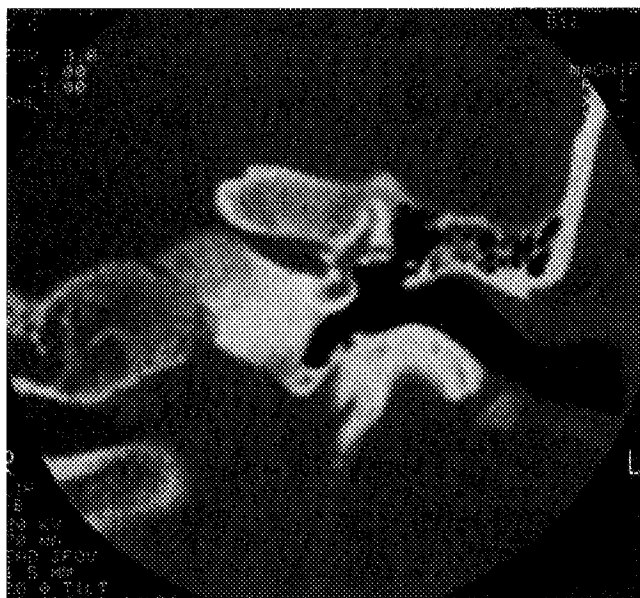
Coronal computed tomographic image of the left-side temporal bone showing severe narrowing of the porus of the internal auditory canal. There is no involvement of the otic capsule, middle ear, or external auditory canal.
